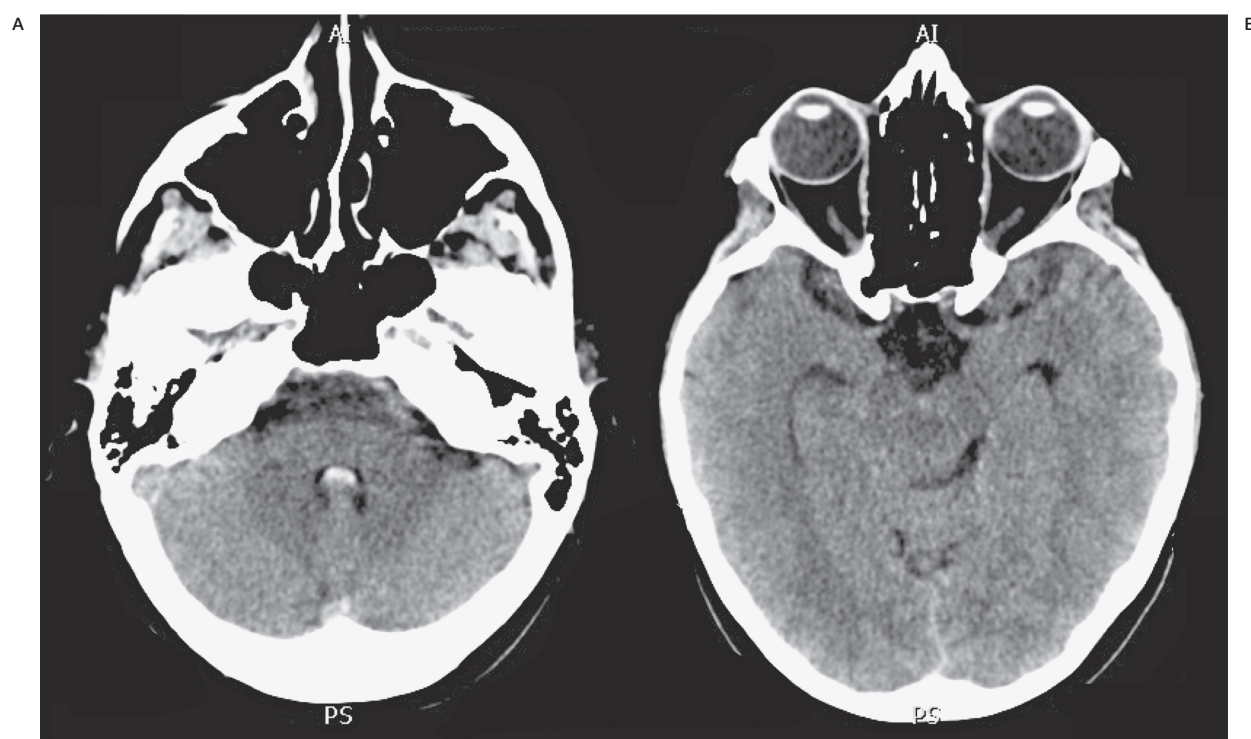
Initial head CT scan. Axial slices at the level of the fourth ventricle (A) and mesencephalus (B). Hyperdense (70HU) occupation of the fourth ventricle and interpeduncular cistern is seen, corresponding to blood products in the subarachnoid space. No other anomalies were seen in the remaining study, including and intracranial CTA (not shown).
